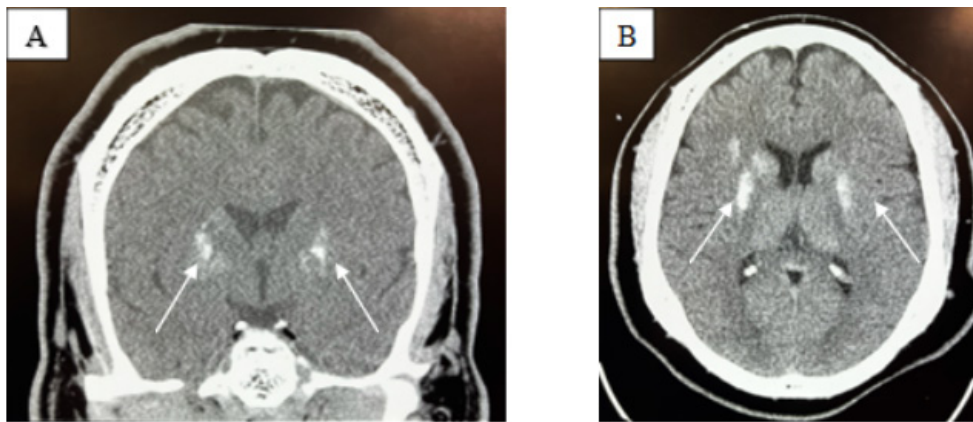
Non-contrast computed tomography of the head: (A) coronal view, and (B) axial view, demonstrating bilateral basal ganglia calcifications (white arrows) in a patient with Fahr disease.
